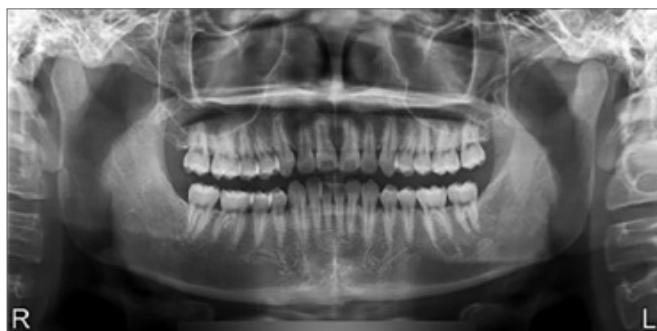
One year of radiographic follow-up showing total bone healing.
